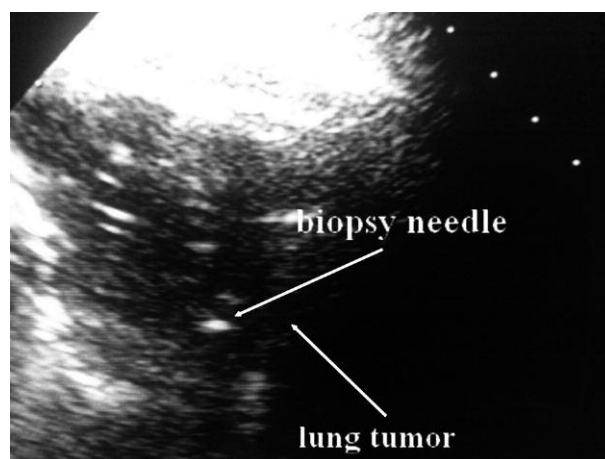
Ultrasound imaging scan – wall located left lung tumor – biopsy needle
